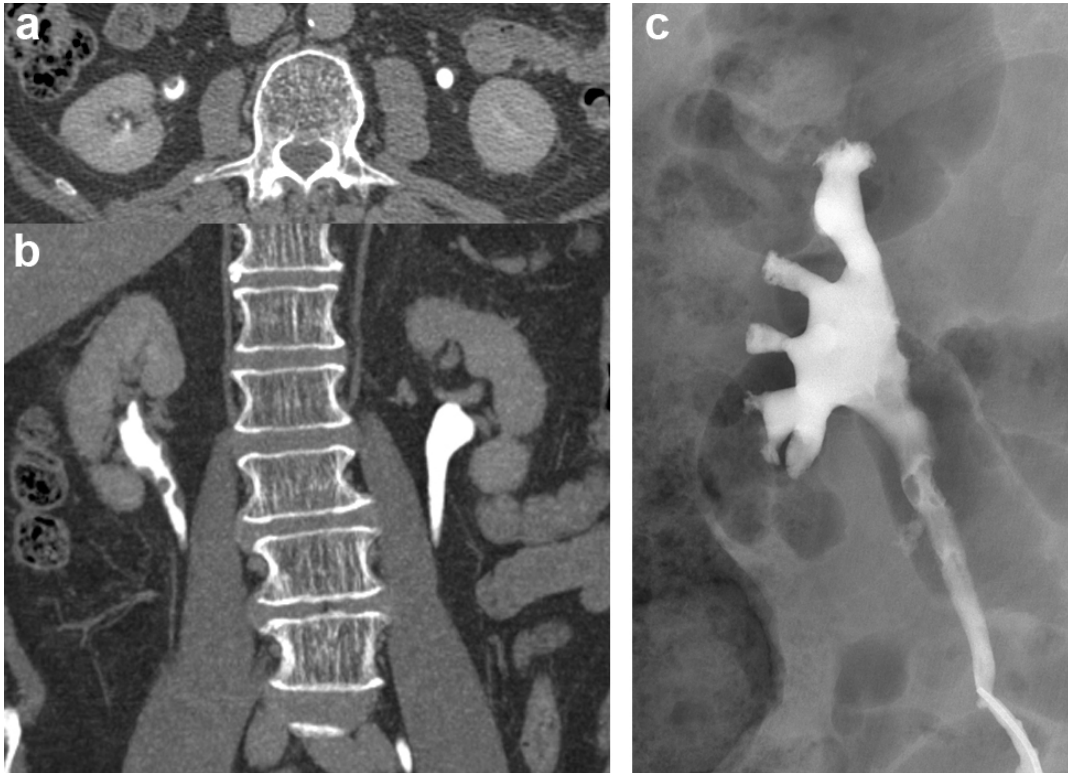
75M with stage Ta UTUC of the right renal collecting system and stage T1 carcinoma of the bladder. (a) Axial and (b) coronal images from excretory-phase CT urography demonstrates tumour, confirmed on subsequent (c) RUP and biopsy.
